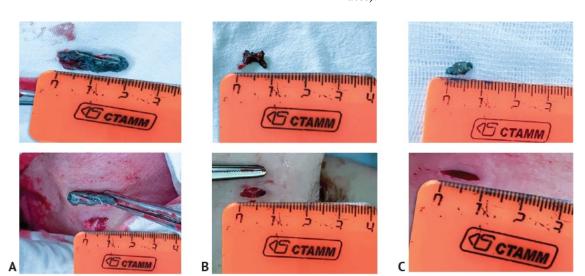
Top: Removed foreign bodies located in the area of the common carotid artery (A), brachial vein (B), and popliteal artery (C). Bottom: The corresponding surgical approaches used to remove these foreign bodies under intraoperative ultrasound navigation
